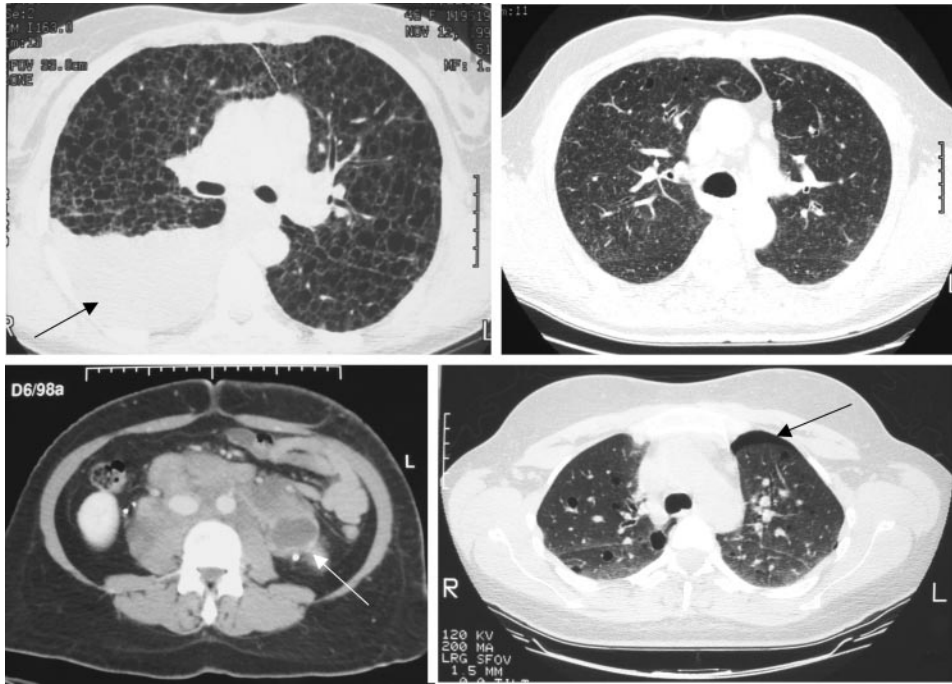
Radiographic manifestations of LAM. *Top left*: HRCT scan of patient with diffuse cystic change consistent with LAM and a large right chylous effusion (arrow). *Top right*: HRCT scan manifestations of micronodular pneumocyte hyperplasia-note diffuse miliary pattern. *Bottom left*: abdominal CT scan demonstrating extensive retroperitoneal adenopathy with central low attenuation consistent with a cystic abdominal lymphangiomyoma (arrow). *Bottom right*: HRCT scan manifestation of mild LAM with a small left apical pneumothorax (arrow).
